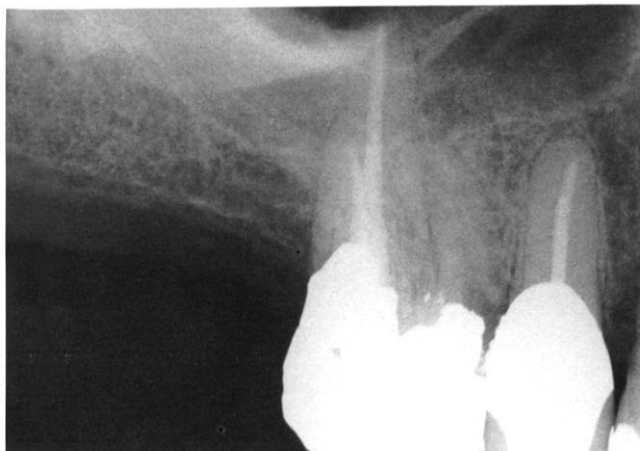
Radiograph shows obturation of palatal and distobuccal canals.
